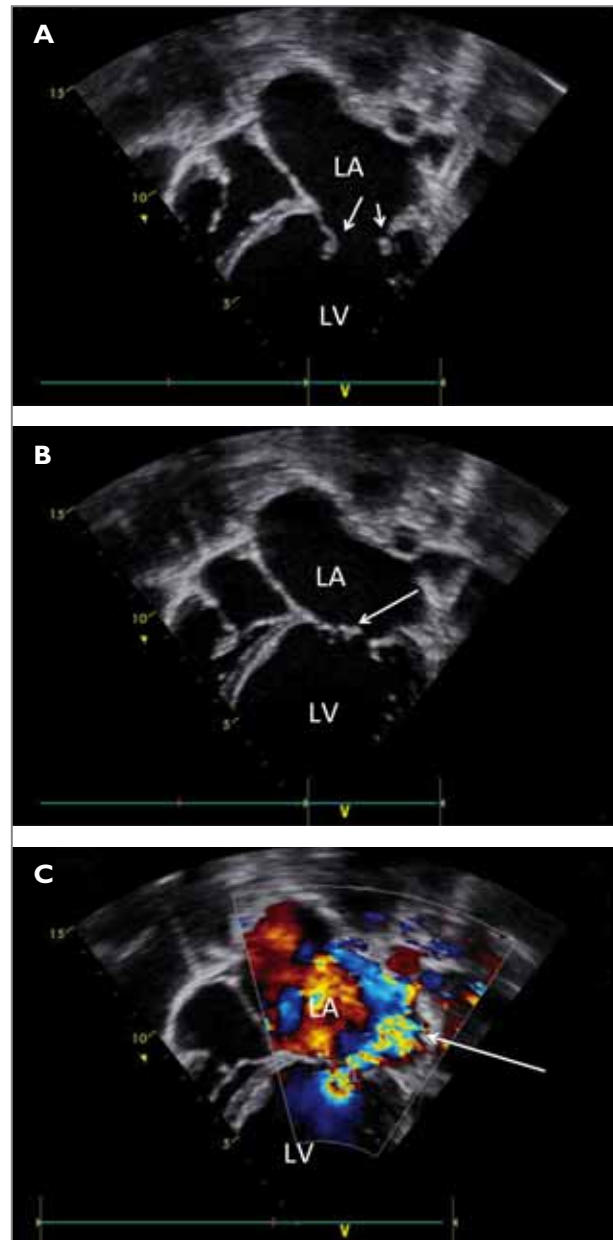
2D echocardiogram in apical 4-chamber view in a patient with advanced rheumatic heart disease. The left atrium (LA) is severely dilated, and the mitral valve leaflets demonstrate the characteristic “rolled appearance” at the leaflet tips as well as poor leaflet excursion during diastole secondary to shortening of the mitral valve chords and mitral commissural fusion.
